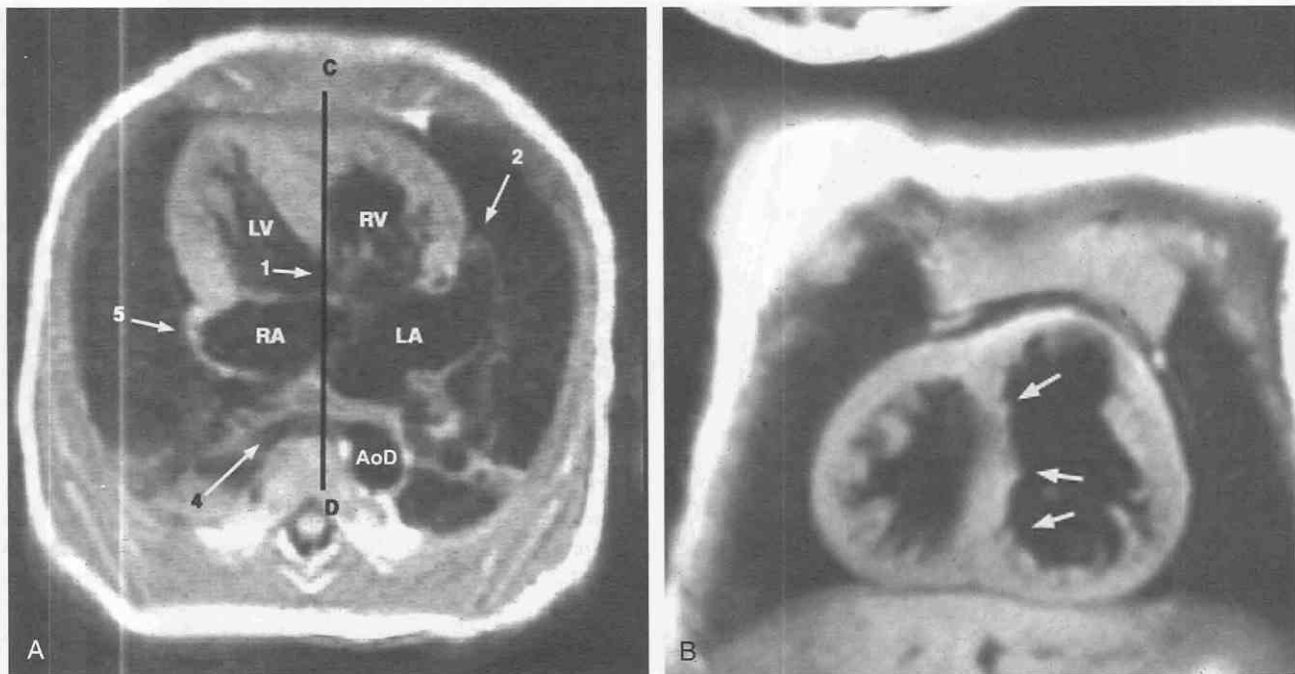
MR image obtained from a 7-month-old boy with situs solitus, corrected transposition of the great arteries, ventricular septal defect (VSD), and pulmonary atresia.
